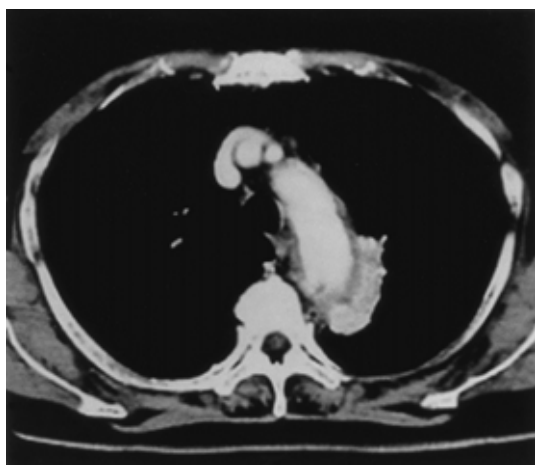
An enhanced CT scan shows a contrast-enhanced mass around the aortic arch. There is no evidence of an intimal flap or false lumen.
